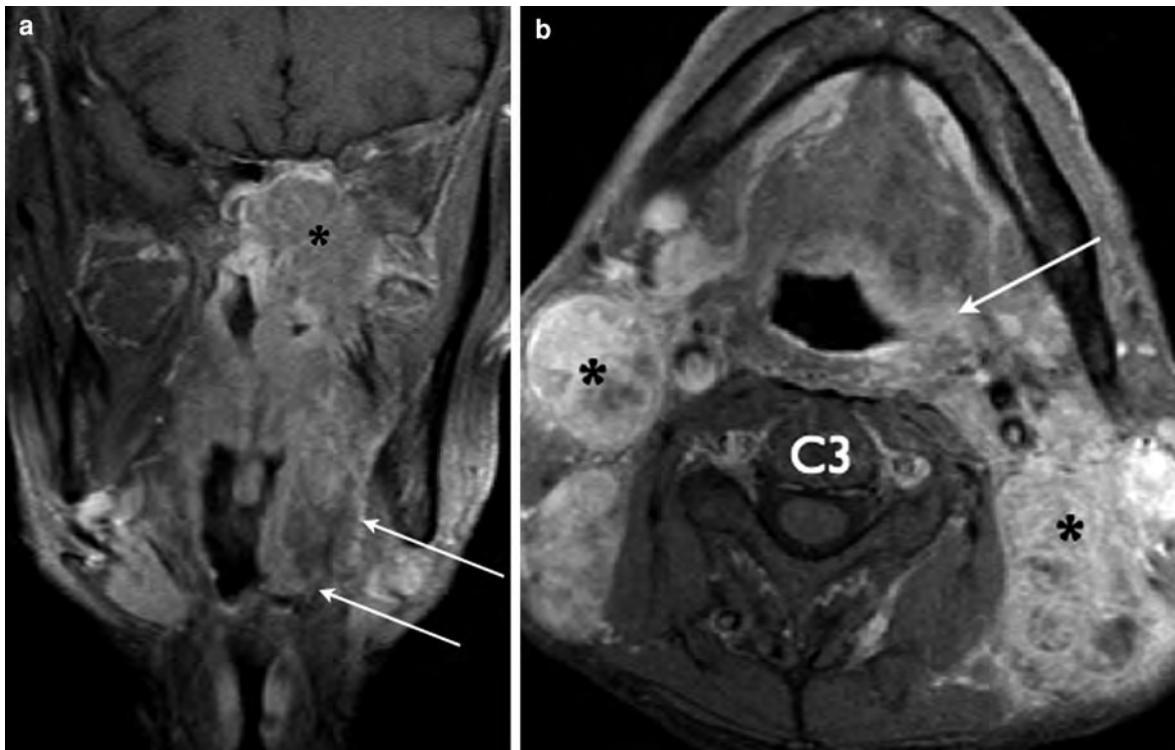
a Coronal contrast-enhanced fat-saturated T1-weighted MR image shows a large left-sided nasopharyngeal carcinoma with skull base erosion and intracranial extension (*asterisk*), as well as inferior spread into the oropharynx (*arrows*). b Axial
